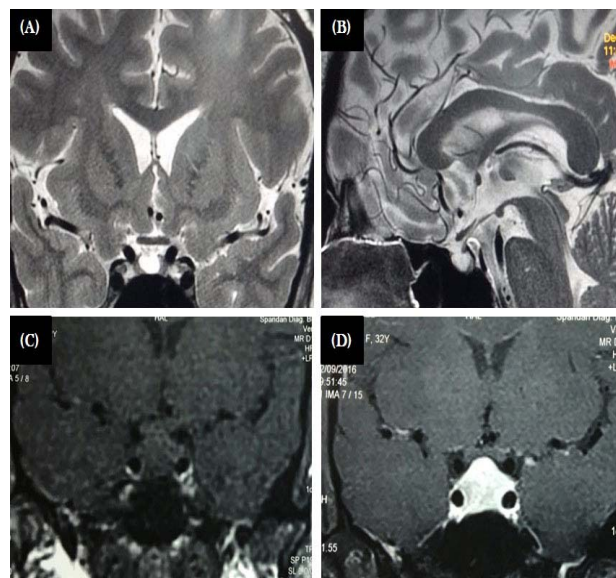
Upper panel: Partial empty sella in T2 weighted MRI (A: coronal; B: mid-sagittal) from a patient of VSB.
